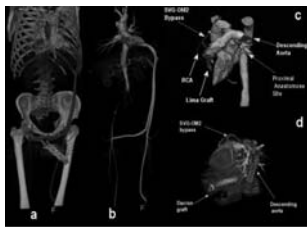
Postoperative Multislice CT view of patient two. Aortobifemoral and left femoropopliteal bypass operation is shown. Figure 2c and 2d: Postoperative Multislice CT view of patient two demonstrating the coronary bypasses and the proximal anastomosis of the Dacron graft. SVG: Saphenous vein graft; OM2: Second obtuse marginal branch of circumflex artery; LIMA: Left internal mammary artery
